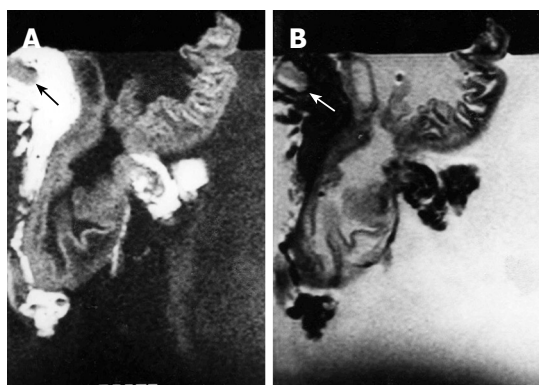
MRI of N1 gastric adenocarcinoma. A: T1-weighted (500/20) MR image showed single lymph node on lesser curvature site of stomach body (arrow); B: T2-weighted (2000/90) MRI showed intermediate signal SI of lymph node (arrow).
